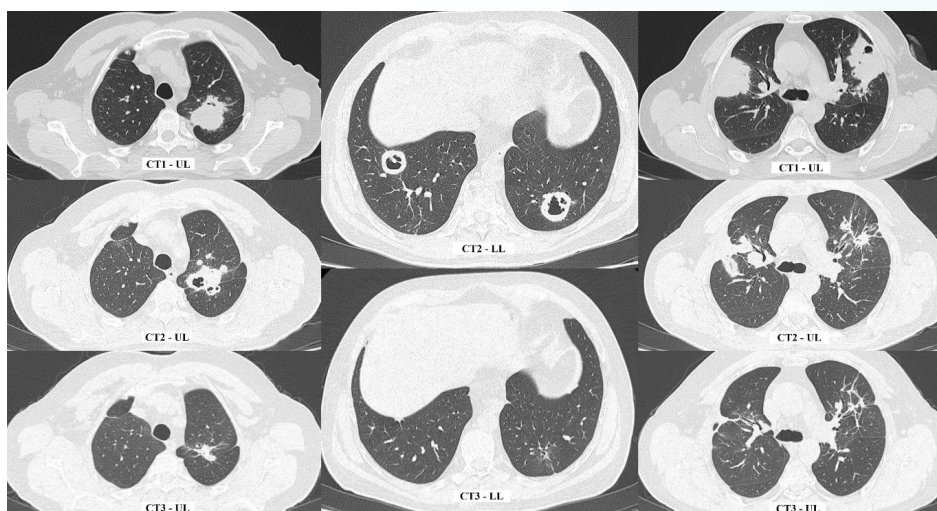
CT scan - Favorable imaging evolution with a numerical and dimensional reduction of the lesions. CT1 - CT performed at the time of diagnosis. CT2 - CT performed post-therapy with cyclophosphamide. CT3 - CT performed post-therapy with rituximab. UL - upper lobes. LL - lower lobes
